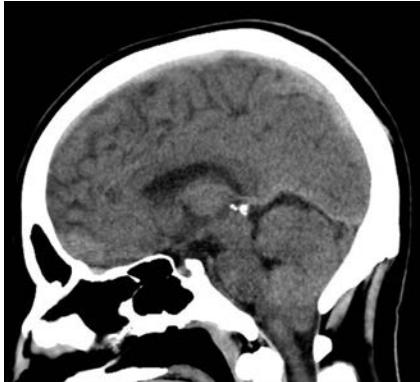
Sagittal CT head.
